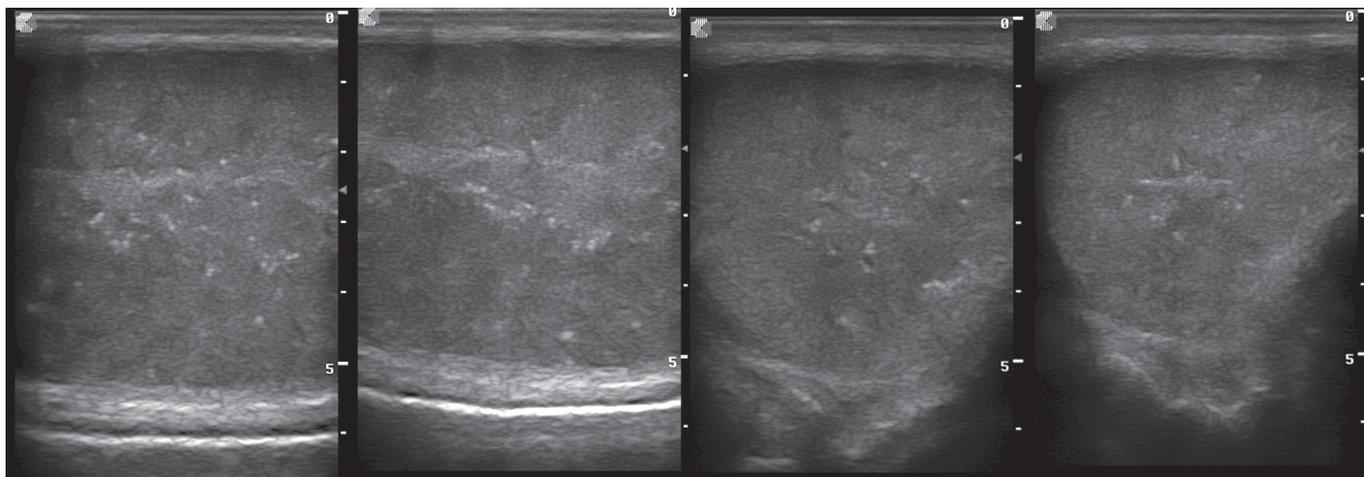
Ultrasonogram of the testis in an aged ram showing evidence of testicular degeneration and fibrosis (echogenic specks within the testicular parenchyma)
